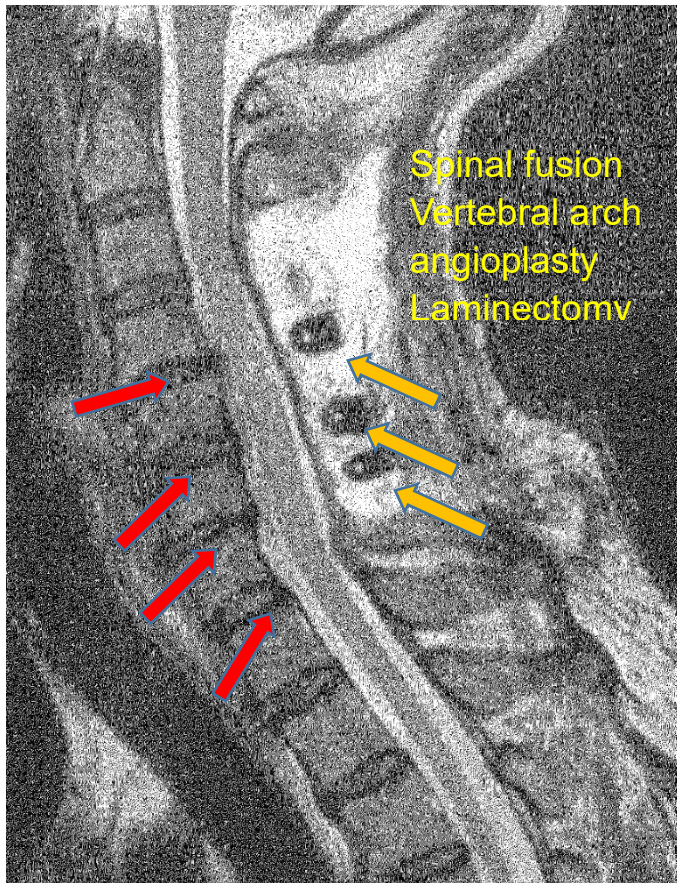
Case 2, post-operative CT image (at the time of first visit)
